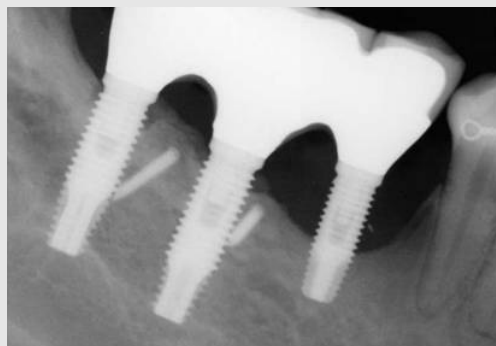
Peri implantitis on both mandibular posterior implant prosthesis. (Panorama and periapical view)
